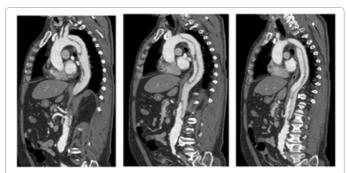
CT images on admission. CT shows acute type B aortic dissection without malperfusion. CA, SMA and It. RA supplied from the true lumen. Rt. RA supplied from the pseudo lumen.
